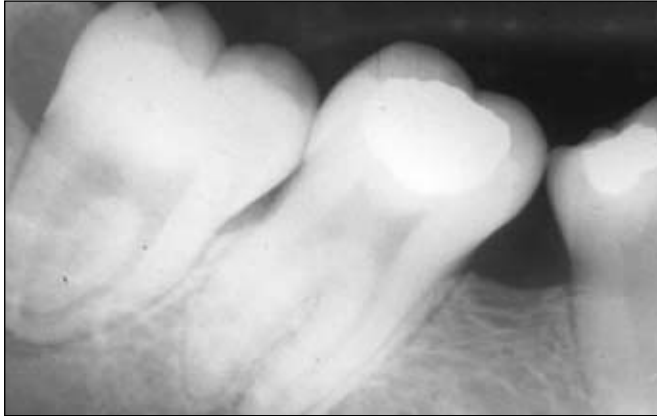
(a): Periapical radiograph showing typical associated radiolucency in pericoronal infection.
